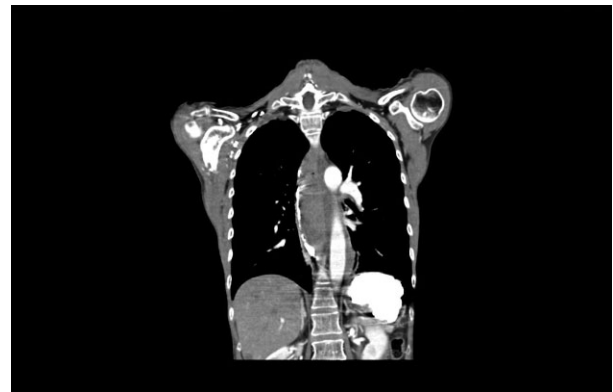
Coronal image of computed tomography of thorax showing the length of dissecting intramural hematoma and displaced narrowed lumen.
